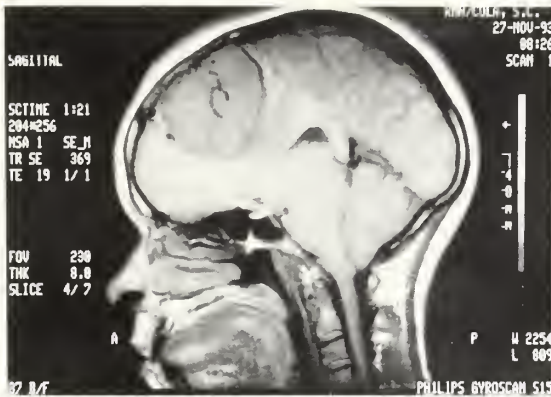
MRI scan showing frontal meningioma.
